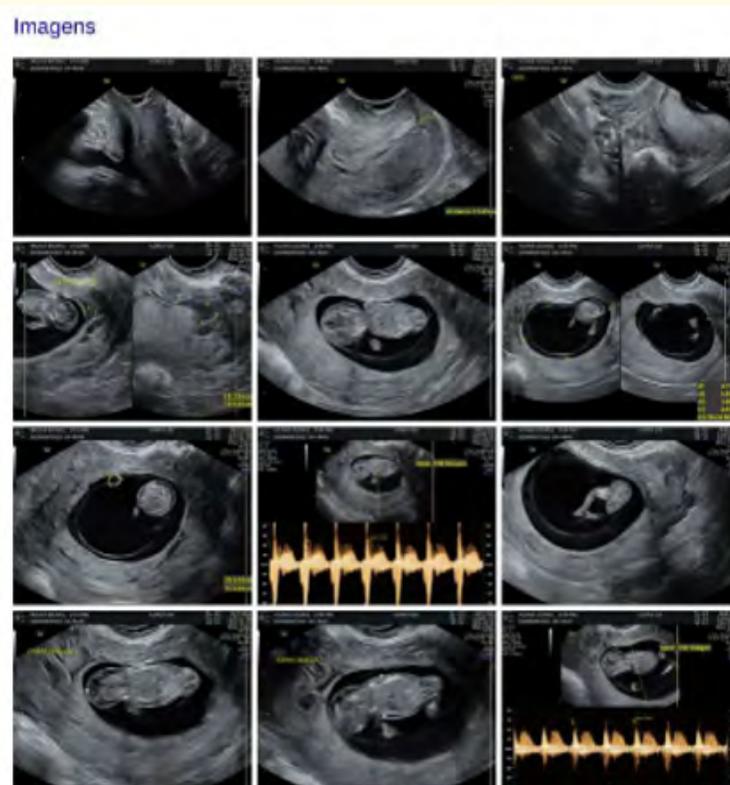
Obstetric ultrasound demonstrating generalized fetal subcutaneous edema (“double contour”). The markings indicate fluid accumulation in the subcutaneous cellular tissue. Fetal heart rate of 185 bpm. Examination performed while on enoxaparin 80 mg/day (10 weeks and 4 days).
